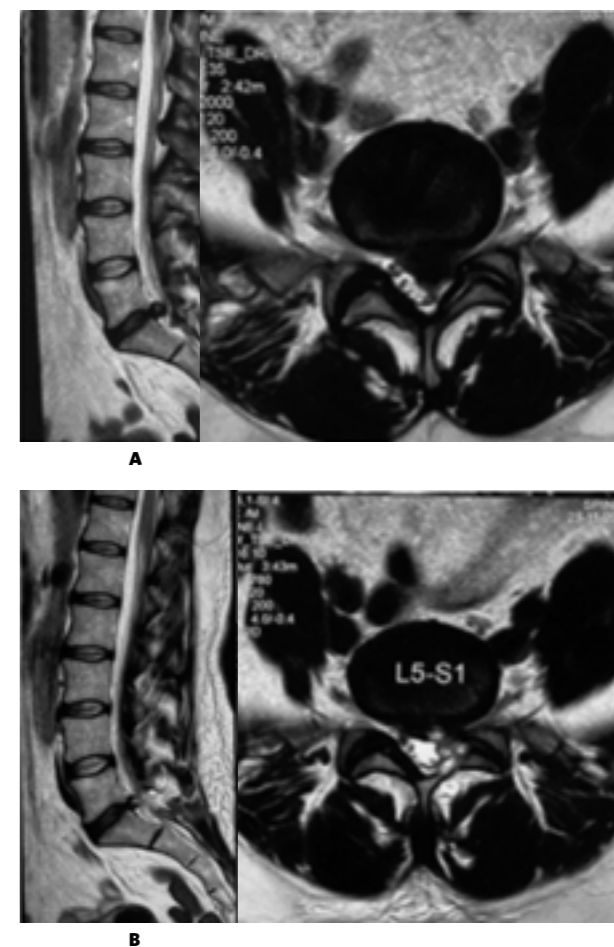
Magnetic resonance imaging of the lumbar spine: A — before surgery, sequestered herniated intervertebral disc L5-S1 with discradicular conflict on the left; B — after surgery, postoperative defect in the left side of the L5 vertebral arch and postoperative changes of intervertebral disc L5-S1 in the left paramedial segment are revealed, sequester removed, L5 spinal root on the left is freed
